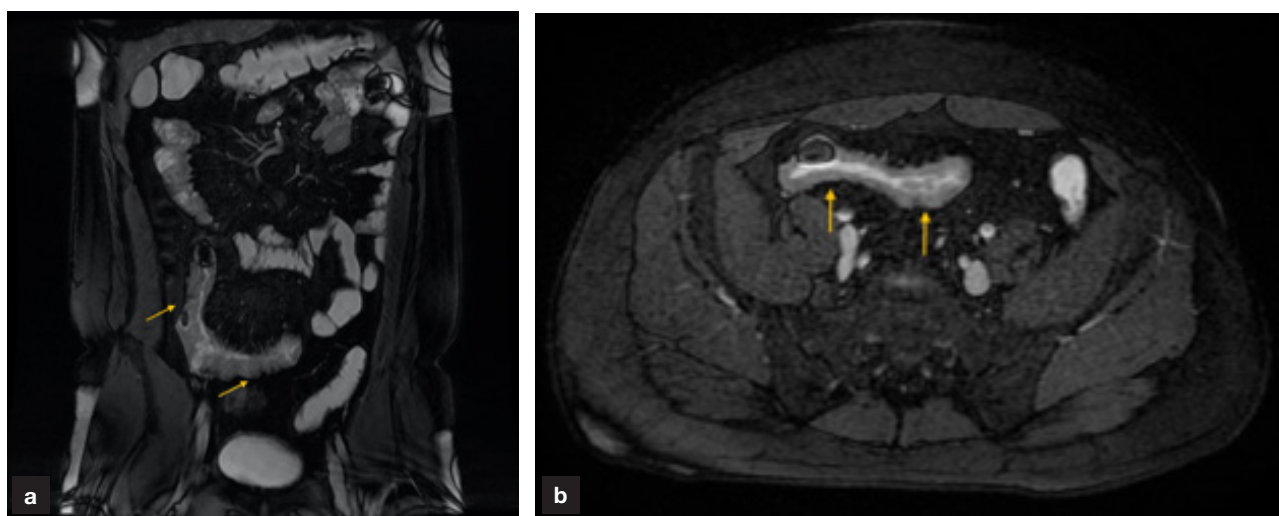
a. Coronal and (b) axial magnetic resonance images (FIESTA FAT-SAT) demonstrating high signal distal ileal wall thickening (oedema) and mesenteric hypervascularity ('comb sign') in a patient with inflammatory Crohn's disease (arrowed).
